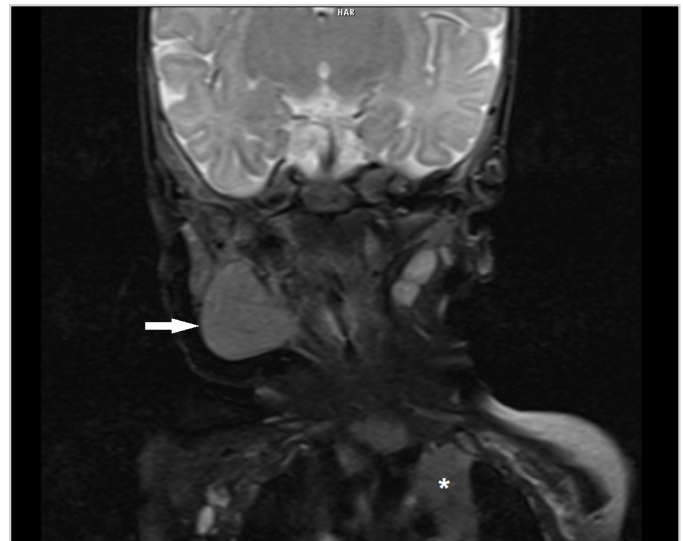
MRI of the neck showing ECT (arrow) is in the same intensity as the normal thymus tissue (asterisk)
